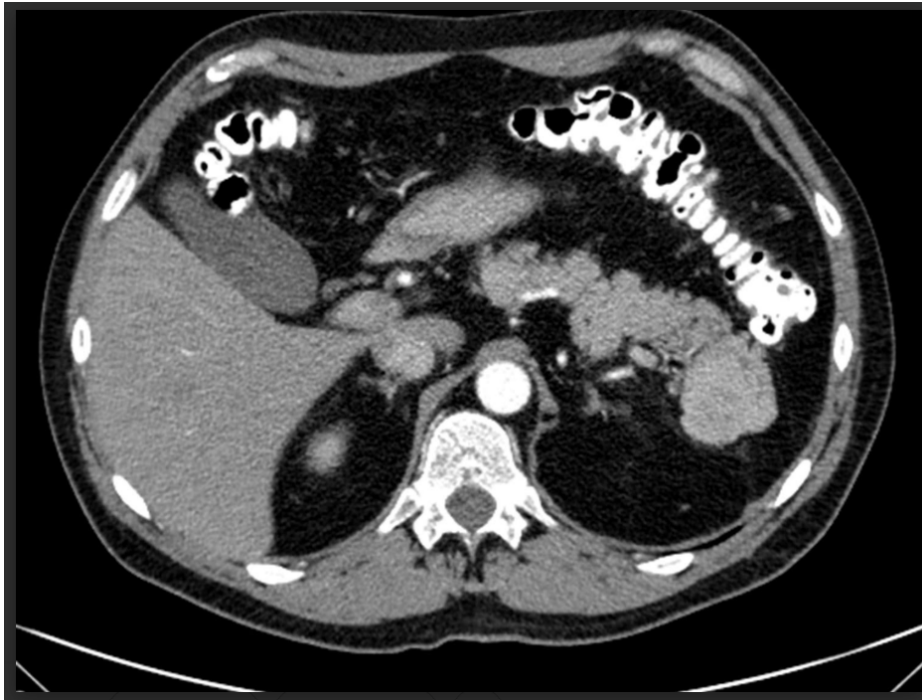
CT scan from August 2016
